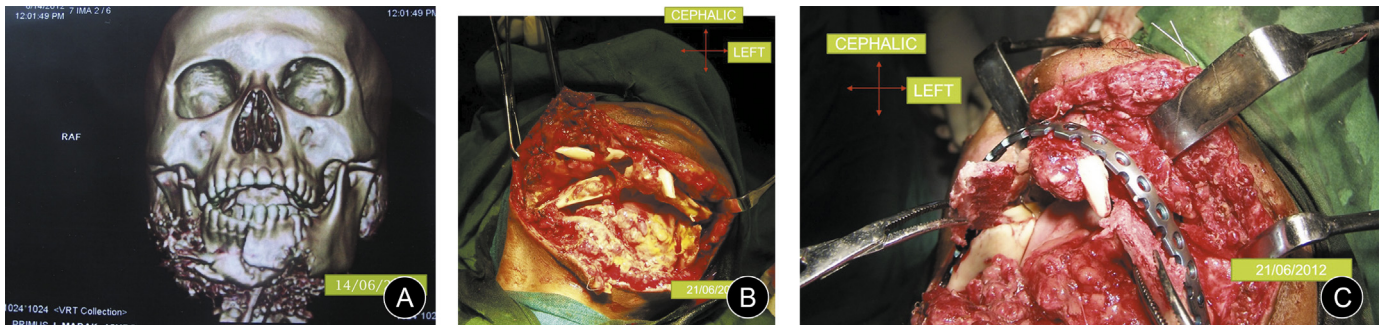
A: CT scan in faciomaxillary region with three-dimensional reconstruction. B: Intraoperative exposure of the fractured mandible due to gunshot wound. C: Reconstruction plate placed from body to body of mandible.
